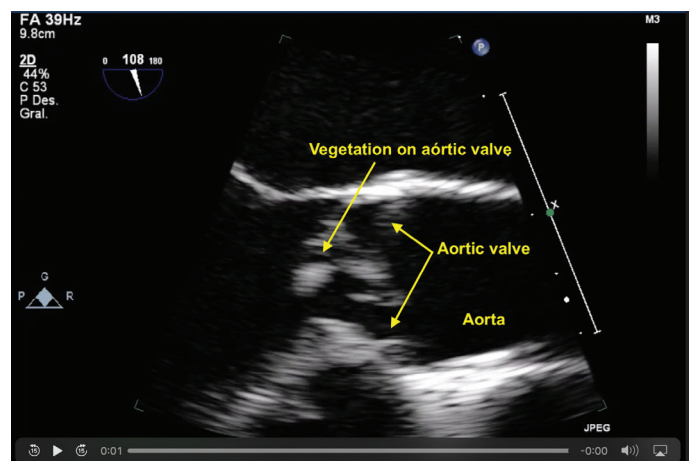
Ultrasonographic confirmation of the presence of vegetation on native aortic valve
